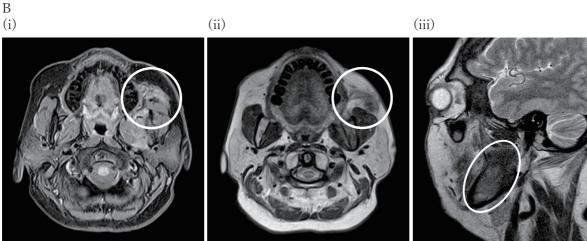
High-permeability tumor shadow is visible in the masticator space. In plain CT, the CT value is similar to that of muscle (A). In a T1-weighted fat-suppressed image (Dixon method), the tumor shadow is hyperintense relative to adipose tissue (i). In a T2-weighted fat-suppressed image (Dixon method), the tumor shadow is somewhat hypointense (ii), (iii). Edema is present in the adjacent masseter and maxillary bone marrow (ii), (iii). Image searches with contrast could not be performed due to renal impairment.
